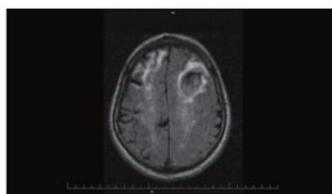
FLAIR image with second episode of acute bleed in left frontal lobe and sequela of prior bleed with gliosis in right frontal region.
